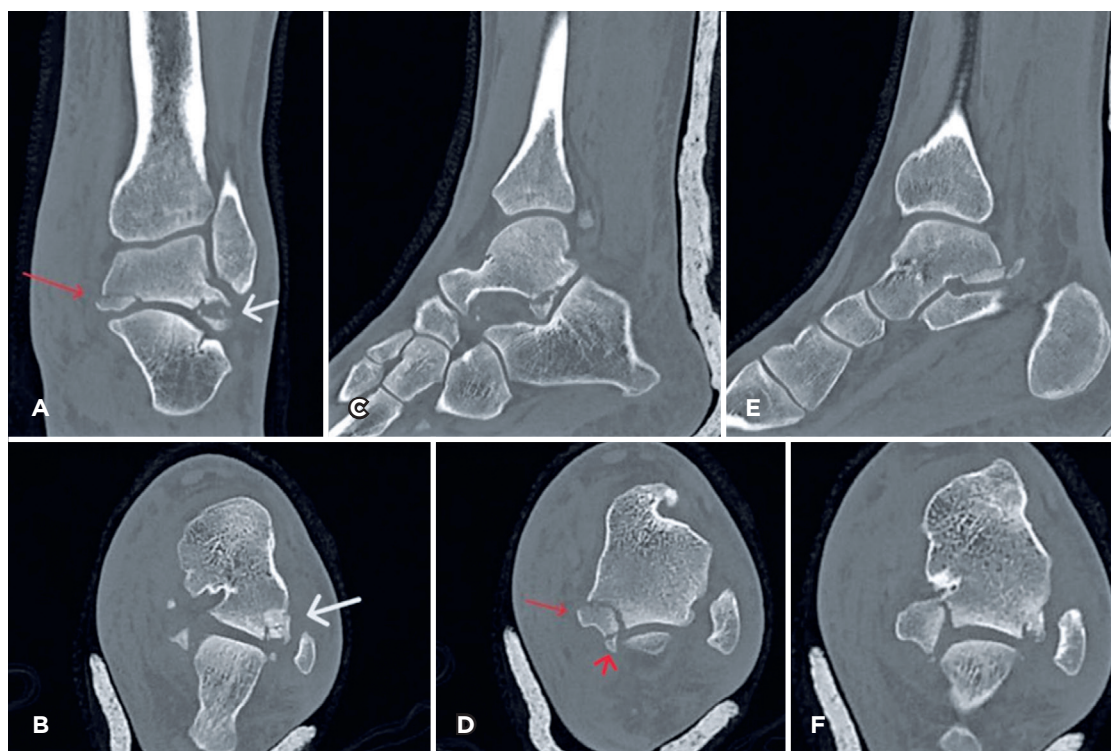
Preoperative computed tomography scan. (A) Coronal section showing a fracture of the lateral process (white arrow) and the posteromedial process (red arrow) (B) Axial view shows comminution of the lateral process (white arrow). (C and E) Sagittal sections demonstrate displaced fractures of the lateral and posterior processes. (D) Axial view with clearly visible Cedell's fracture (thin red arrow) and Shepherd's fracture (red arrowhead). (F) Axial view with synchronous fracture of the lateral and posterior processes.
